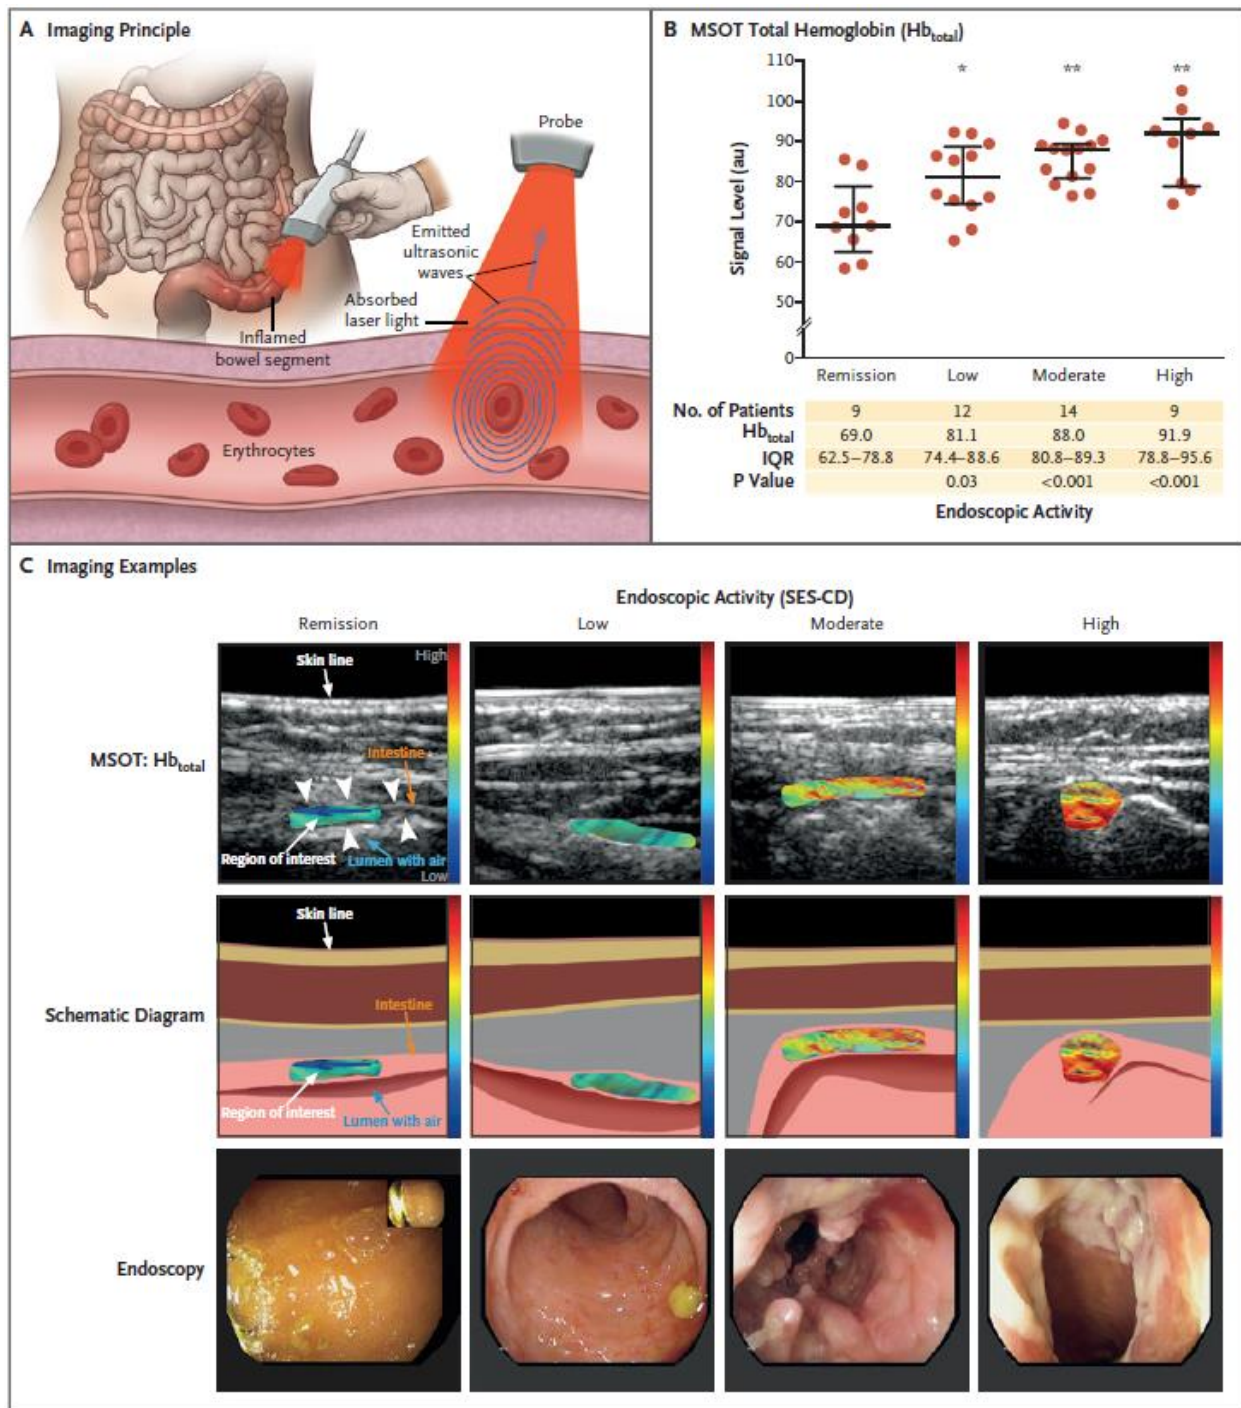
MSOT imaging for the assessment of Crohn's Disease activity (from Ref. [28]). A, the transabdominal imaging approach, which uses the same detector for laser light emission and ultrasonic detection of signal levels by means of MSOT. B, MSOT-derived total Hb signal levels
